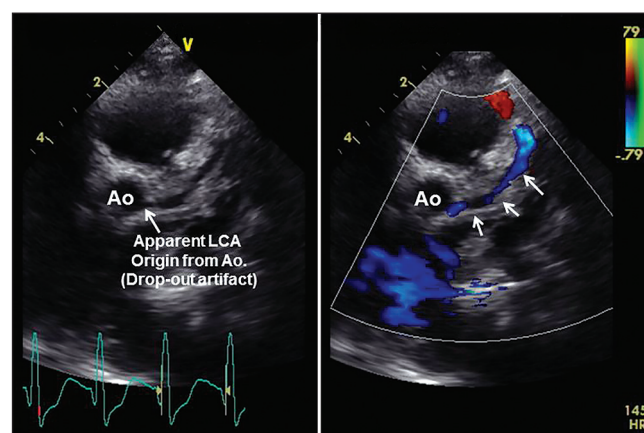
Echocardiogram in parasternal short-axis view from case 1 (10 month old). Panel 1A shows 2D image of aortic root in cross-section with apparent origin of left coronary artery (LCA) from aorta. Arrow points to area of “drop-out” artifact. Panel 1B shows color Doppler imaging of the same area. Blue color indicates reversed direction of flow in left coronary artery (arrows) which is abnormal
